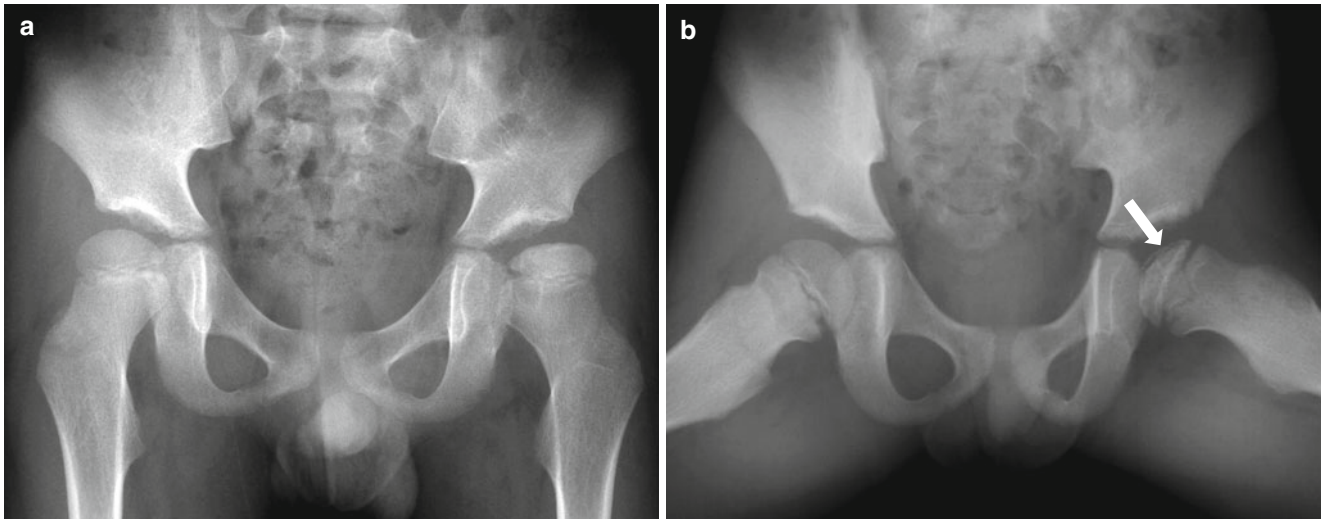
Initial stage of LCP disease. (a) Anteroposterior radiograph in a 5-year-old boy with a left-sided limp shows a dense sclerosis in the left femoral head. (b) Frog-leg lateral view shows subchondral radiolucency (*arrow*) with sclerosis in the left femoral head
